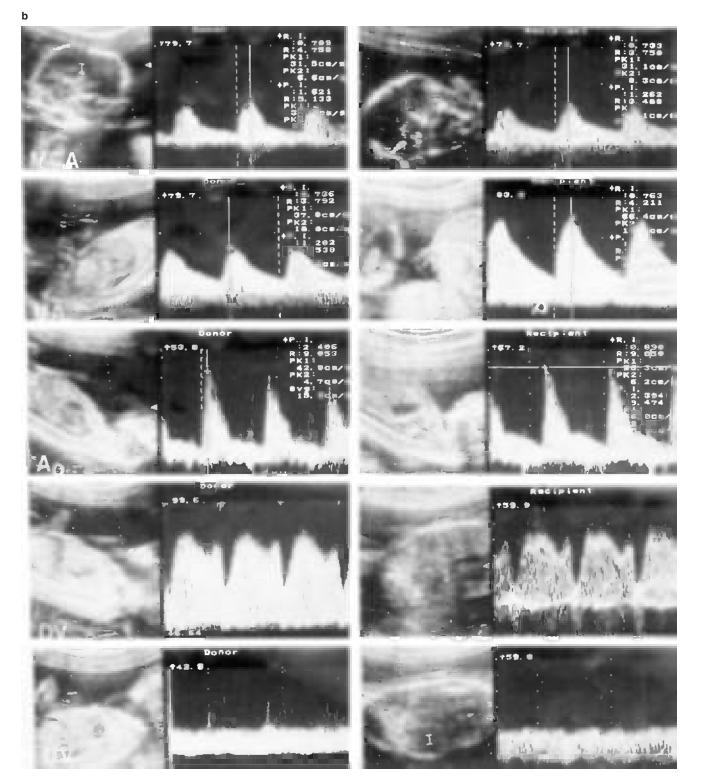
(a) Doppler blood flow waveforms in the umbilical artery (AU) and ductus venosus (DV) obtained in case 3 at 17 weeks of gestation, when twin-to-twin transfusion was detected. In both fetuses, abnormal flow in the DV (decreased velocity during atrial contraction) was recorded. The umbilical artery showed normal blood flow waveforms. Note the 'stuck twin' with oligohydramnios (donor) and the polyhydramnios around the recipient. (b) *Opposite* Normal Doppler blood flow profiles (arterial and venous) obtained in both fetuses (case 3) 1 week after fetoscopic laser coagulation. MCA, middle cerebral artery; UA, umbilical artery; Ao, descending aorta; DV, ductus venosus; UV, umbilical vein. Reproduced with permission from reference 4
